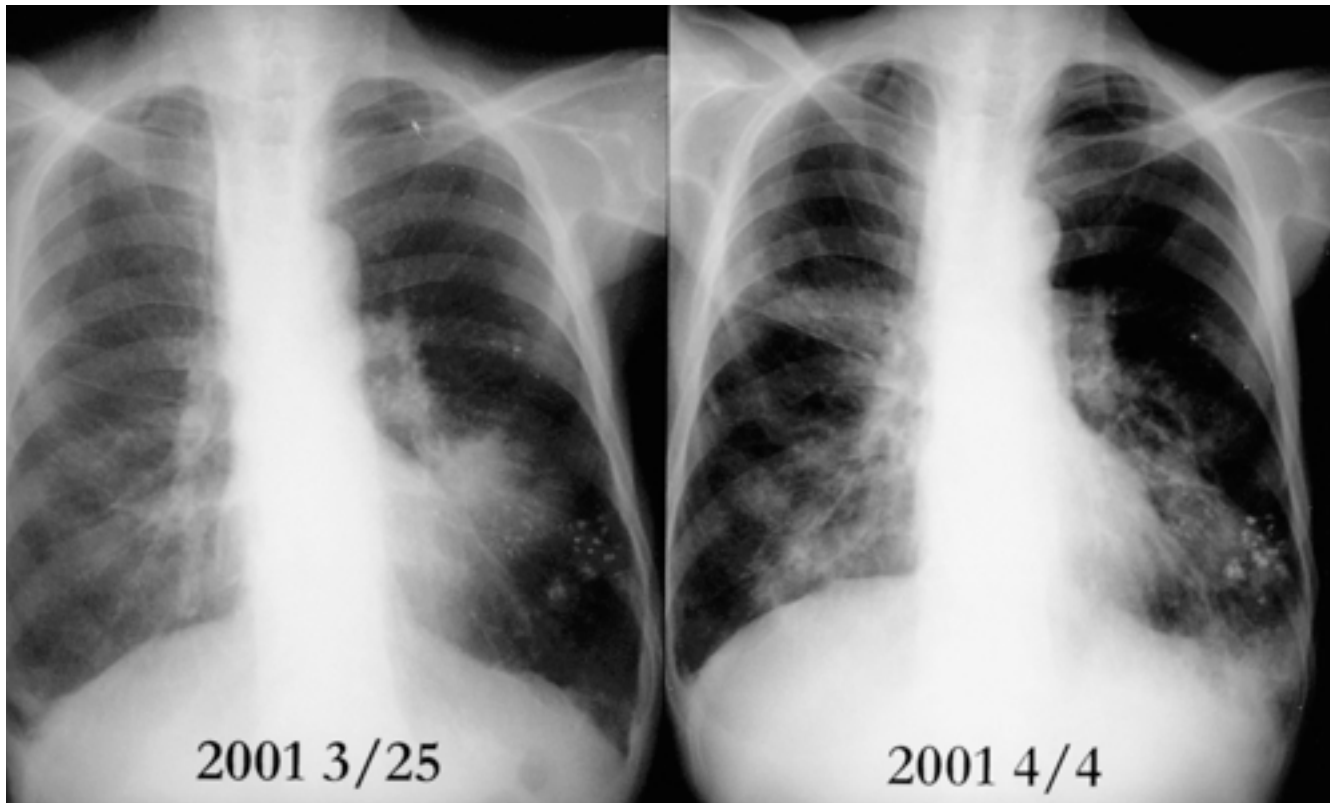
Follow up chest radiography shows no atelectasis or ventilation disturbance in left upper lung.
